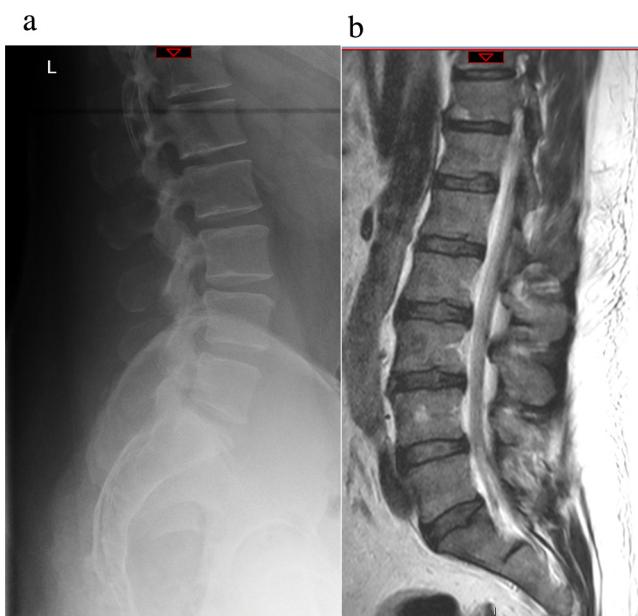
a and b: Plain radiography and T2 weighted sagittal MRI views showing no evidence of discitis.
